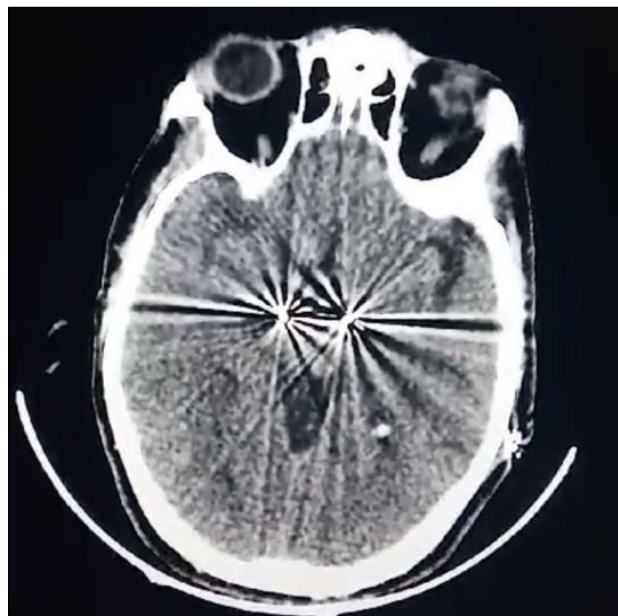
Brain CT of the patient A.A, showing the targeted subthalamic nuclei
